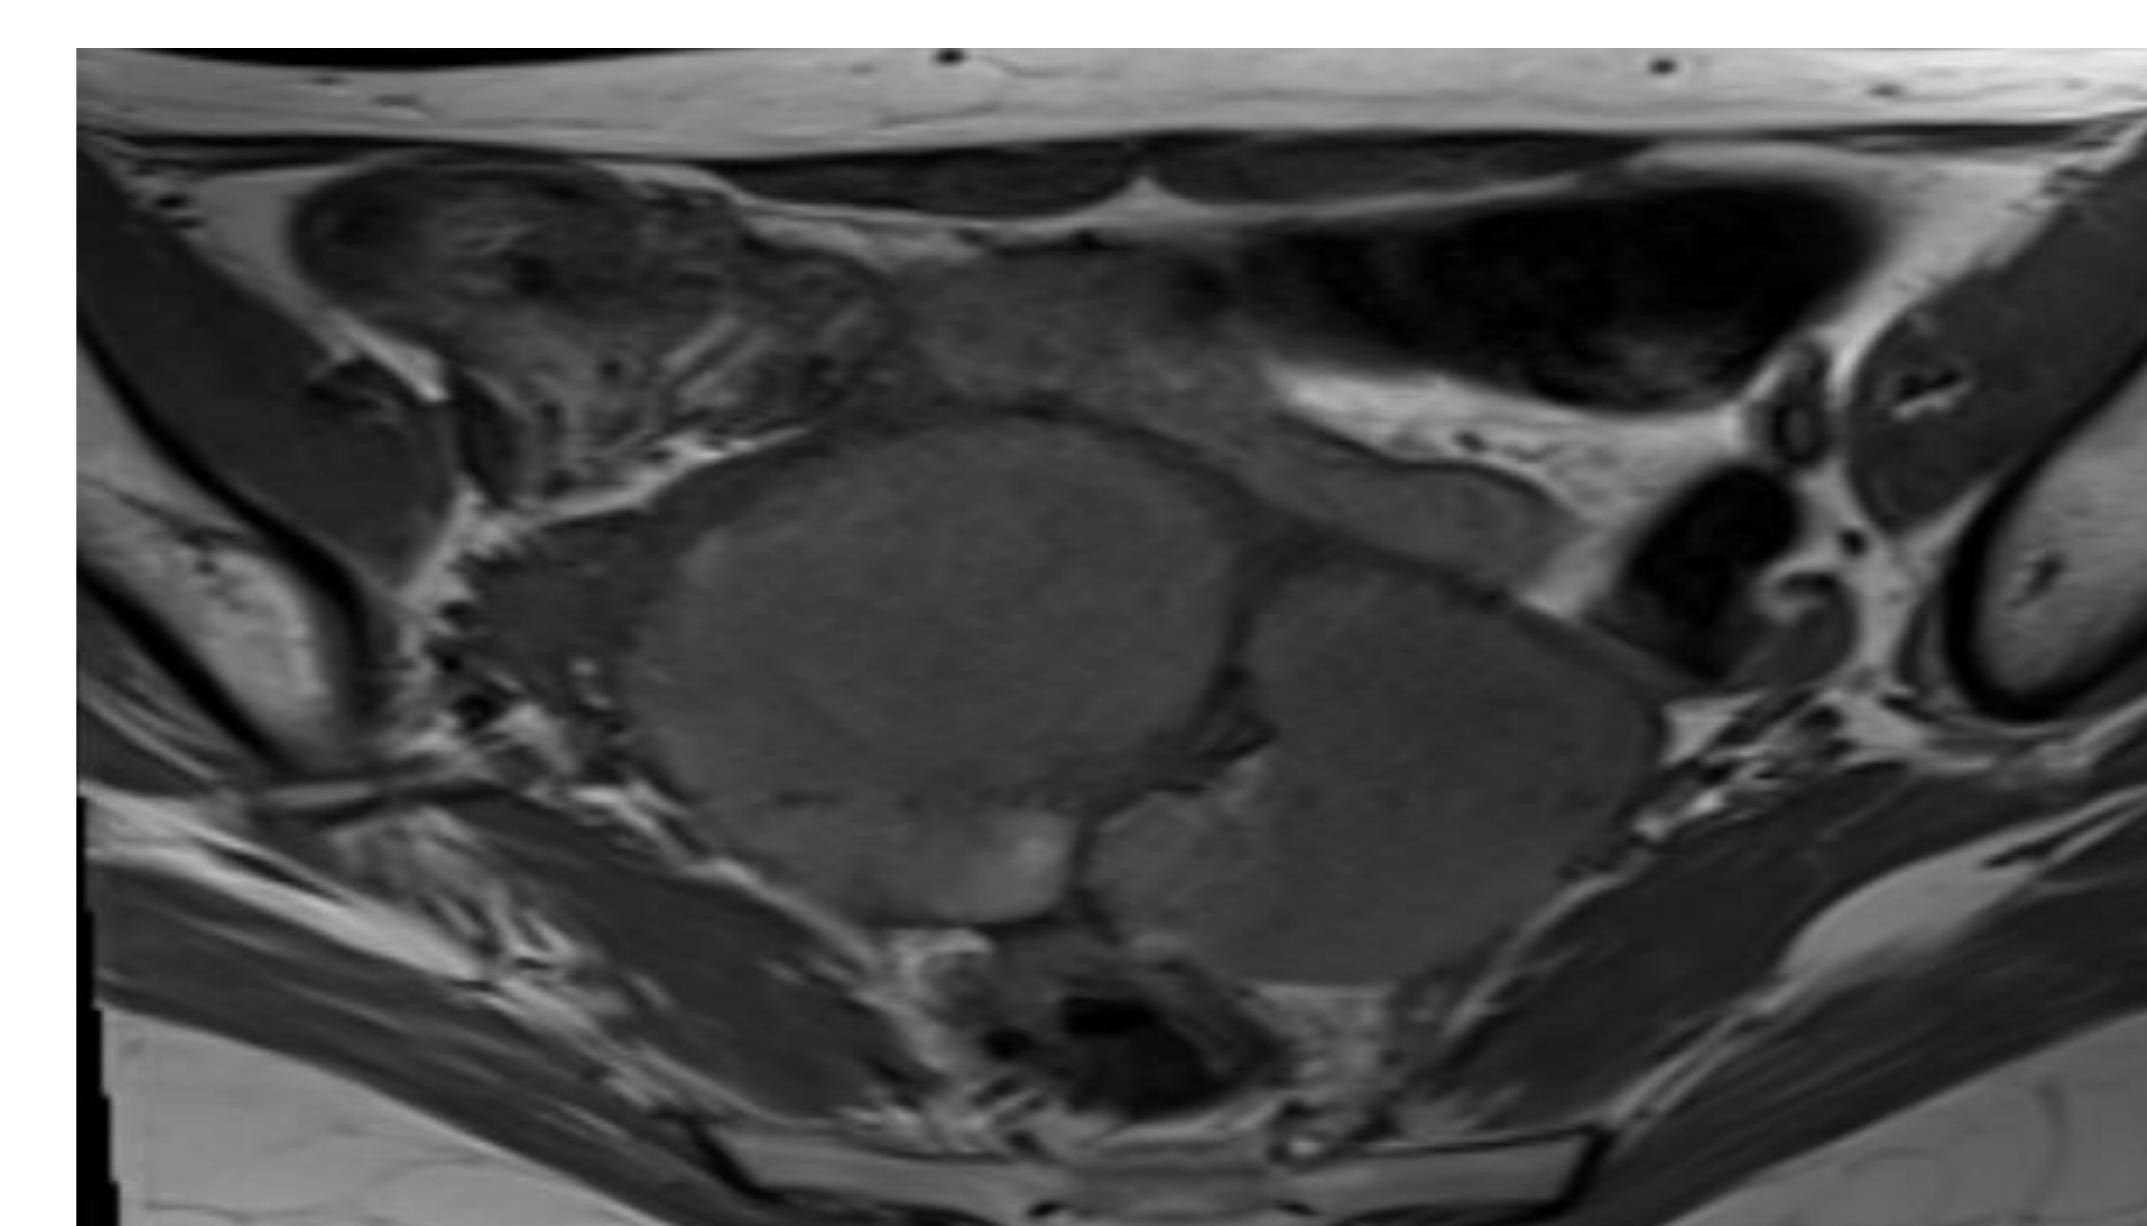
MRI before surgery , mass anterior to the rectum adjacent to the sigmoid colon
